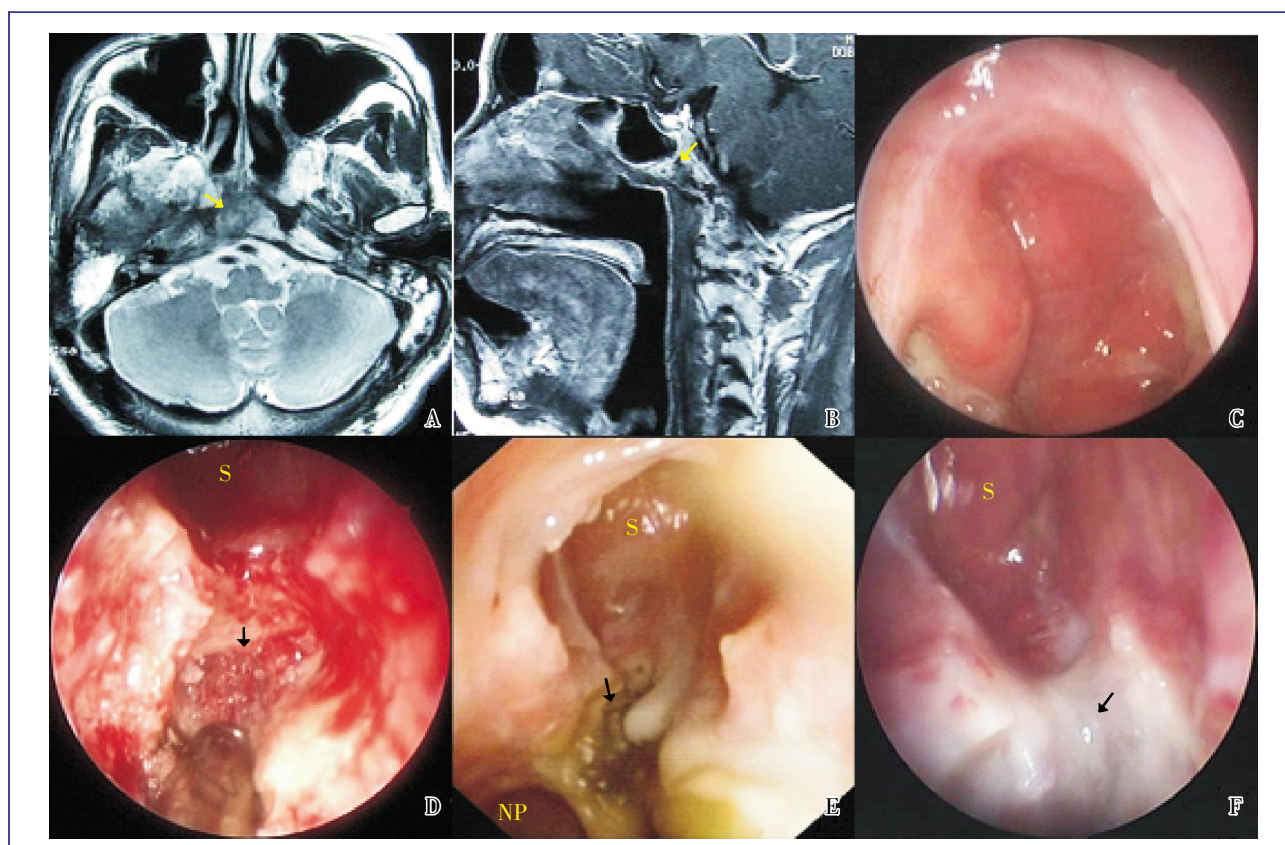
Preoperative examination, operation, and postoperative follow-up in a nasopharyngeal carcinoma (NPC) patient with a postradiation nasopharyngeal skull base lesion. This NPC patient was a 59-year-old man who underwent one course of radiotherapy. The 1-year follow-up MRI shows signals indicating probable malignancy. Postoperative pathology showed osteoradionecrosis. A, T2-weighted image on the axial plane shows normal marrow signal in the right clivus changed to heterogeneous slightly hypointense signal with a patchy, slightly hyperintense signal inside (yellow arrow). B, enhanced T1-weighted image on the sagittal plane shows heterogeneous enhancement in the right clivus lesion with patchy, non-enhanced areas inside (yellow arrow). C, the nasopharynx cavity is normal and there are no signs of recurrence under flexible nasopharyngoscope. D, the right clivus is exposed and abraded for biopsy via transnasal approach (black arrow). E, at the 2-month follow-up after surgery, the endoscopic examination shows the biopsied region covered by a scab (black arrow). F, at the 6-month follow-up after surgery, the endoscopic examination shows mucosal epithelialization and no signs of recurrence in the biopsied region (black arrow). S, sphenoid sinus; NP, nasopharynx.
